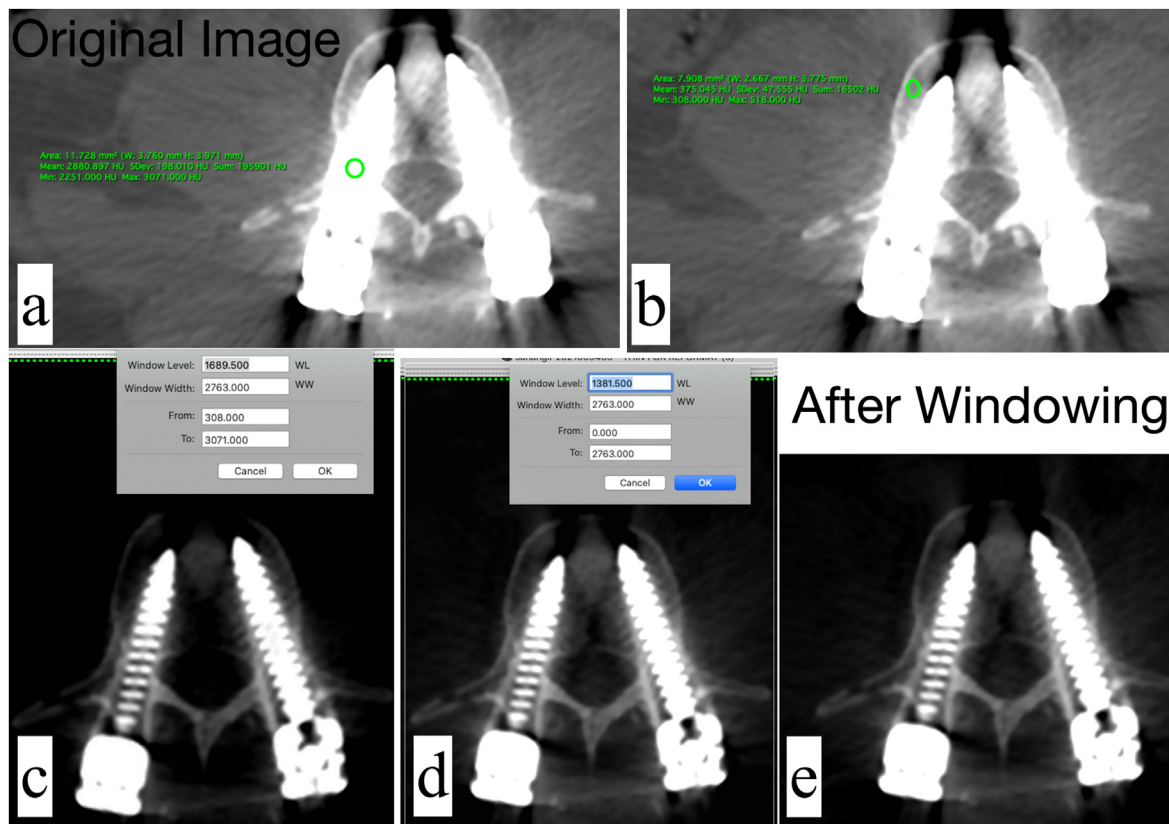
Application of the windowing technique to address metal artifacts in a patient with postoperative spine CT. a) The unprocessed axial section – artifacts are noted around the pedicle screw. The oval region of interest (ROI) tool has been placed over the pedicle screw, its HU values are displayed in the green text. b) The oval ROI tool has been positioned over the vertebral body, the corresponding HU values are displayed. c) The window width has been adjusted. d) The window level has been adjusted e) The final image, showing reduction of metal artifacts.
